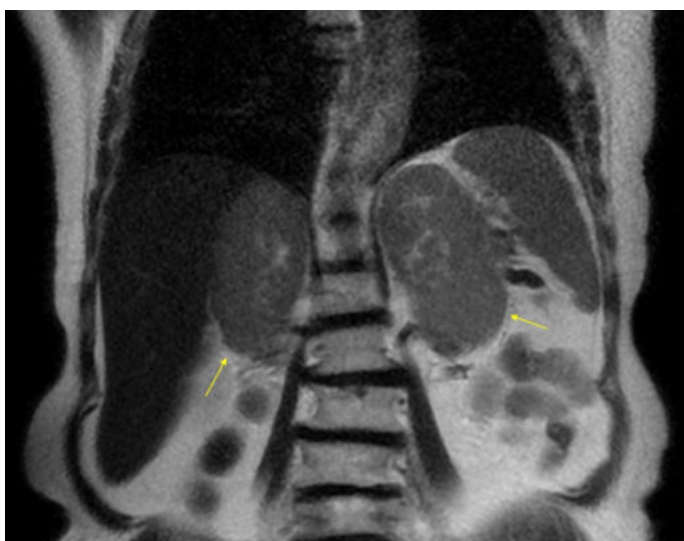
Coronal T2-weighted images, hyperintense mass lesions of uniform character with smooth borders are observed in bilateral adrenal glands.
